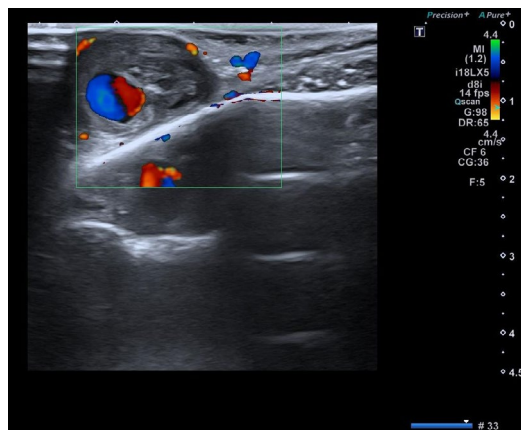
Preoperative Doppler ultrasound image.
